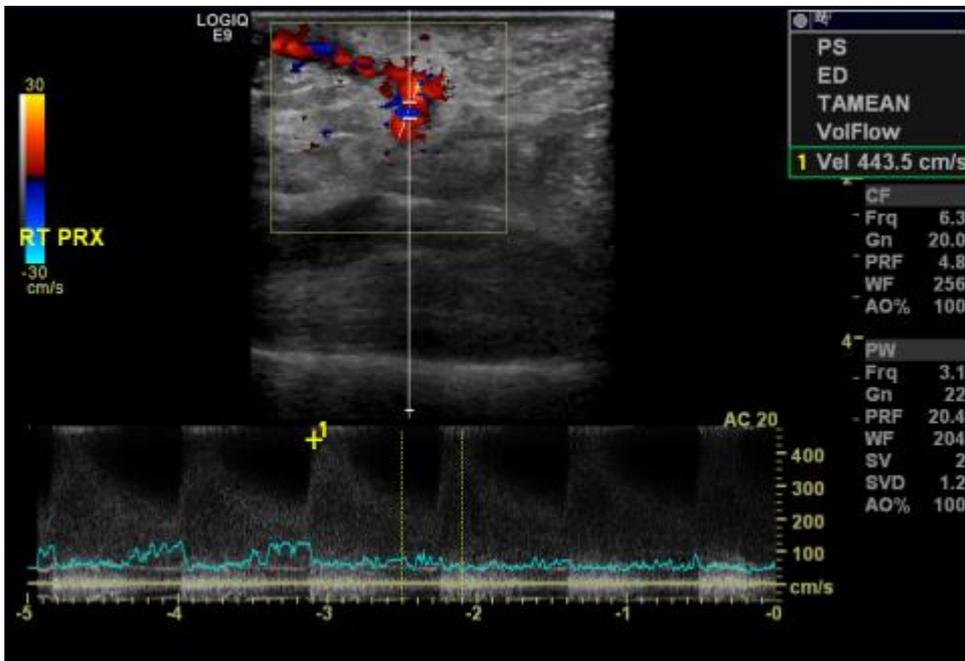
AV fistula outflow vein stenosis as demonstrated by spectral Doppler.
